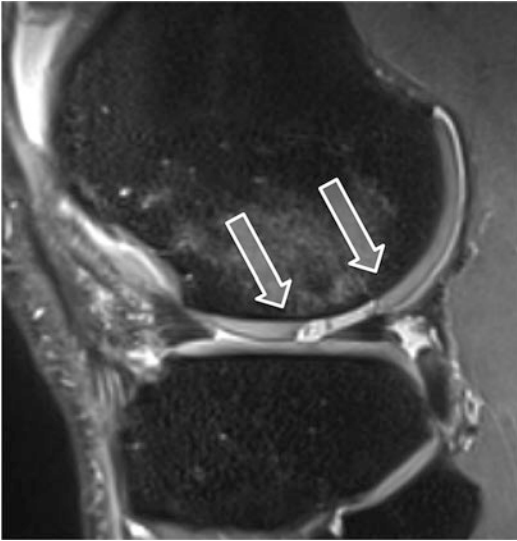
High-resolution morphological fsPD-TSE sagittal MR images of the femorotibial joint as performed on a 3.0 Tesla MRI with an in-plane resolution of 0.4×0.4 mm. The image shows a complete traumatic cartilage defect (ICRS grade 4), with underlying bone marrow edema
